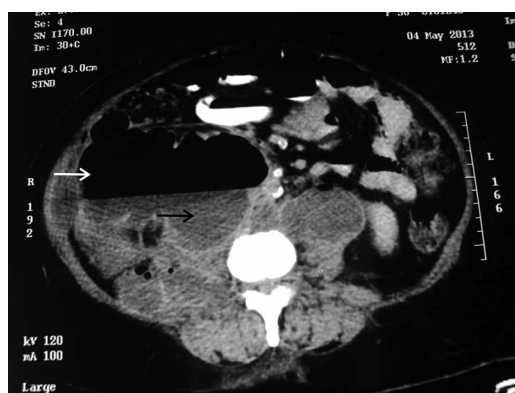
CT image of the large perinephric collection admixed of liquefied necrotic purulent fluid settled at the bottom (black arrow) with air above (white arrow) giving rise to renal air–fluid level suggestive of emphysematous pyelonephritis.
